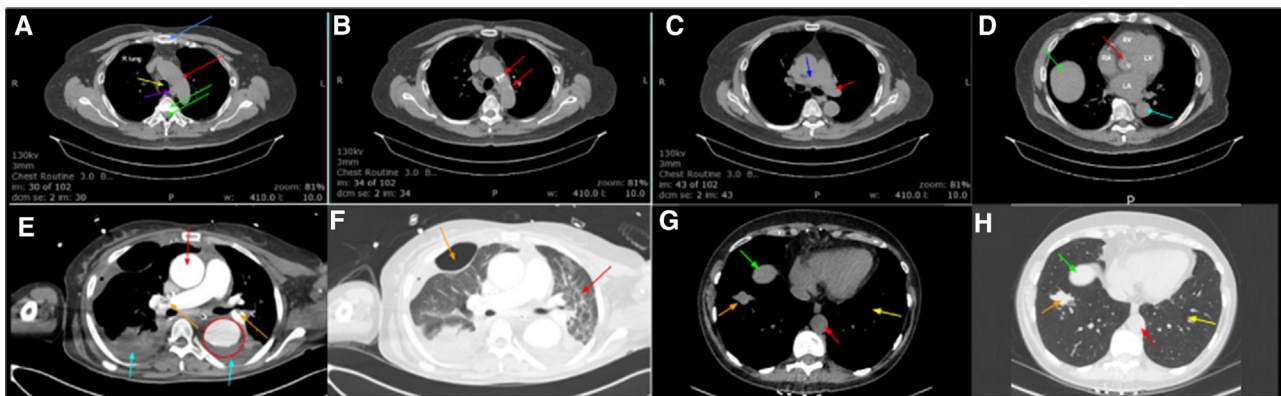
Examples of computed tomography (CT) slices in the axial view. A-D show a preoperative noncontrast CT scan of a patient who later underwent a coronary artery bypass graft surgery. A, The right lung is labeled in text in the image. *Blue arrow:* sternum. *Red arrow:* Aortic arch free of visible calcifications. *Yellow arrow:* trachea. *Purple arrow:* esophagus. *Green arrows:* vertebral body (anterior arrow) medial to the spinal cord (posterior arrow). B, *Red arrows* indicate aortic calcifications at the level of the aortic arch. C, Same study as previous panels, now at the level of the pulmonary trunk bifurcation. *Red arrow* indicates left pulmonary artery, whereas the *blue arrow* indicates the right pulmonary artery. D, Same study as previous panels, now at the level of the heart, with the following structures labeled: “LA” indicates the left atrium, “LV” indicates the left ventricle, “RA” indicates the right atrium, and “RV” indicates the right ventricle. Two portions of the aorta are visible in this slice: the ascending aorta with calcifications visible (*red arrow*), and the descending aorta (*blue arrow*). A portion of the patient’s liver is also visible, indicated by the *green arrow*. E, CT of the chest with contrast in soft tissue window. *Orange arrows:* Filling defects in pulmonary vasculature indicating presence of pulmonary emboli. *Red arrow:* Aneurysm of ascending aorta. *Red circle:* type B aortic dissection, with the circle including both the true lumen (filled with contrast) and false lumen (*dark*). *Blue arrows:* Dependent fluid, concerning either for extensive pleural effusions or chronic hemothorax. F, CT of the chest with contrast in lung window. *Orange arrow:* subcutaneous air, consistent with recent insertion of chest tube in this patient. *Red arrow:* parenchymal changes consistent with chronic lung infection, best appreciated in the lung window of this scan. G, Noncontrast CT of the chest to visualize lung nodule in soft tissue window. Colored arrows represent the following: *orange arrow:* lung nodule. *Red arrow:* descending aorta. *Green arrow:* superior border of liver. *Yellow arrow:* inability to appreciate lung markings compared with H, which shows lung fields with lung windowing. *Orange arrow:* lung nodule. *Red arrow:* descending aorta. *Green arrow:* superior border of liver. *Yellow arrow:* lung markings. All images with permission of Dr Ahmet Kilic of Johns Hopkins Hospital.
